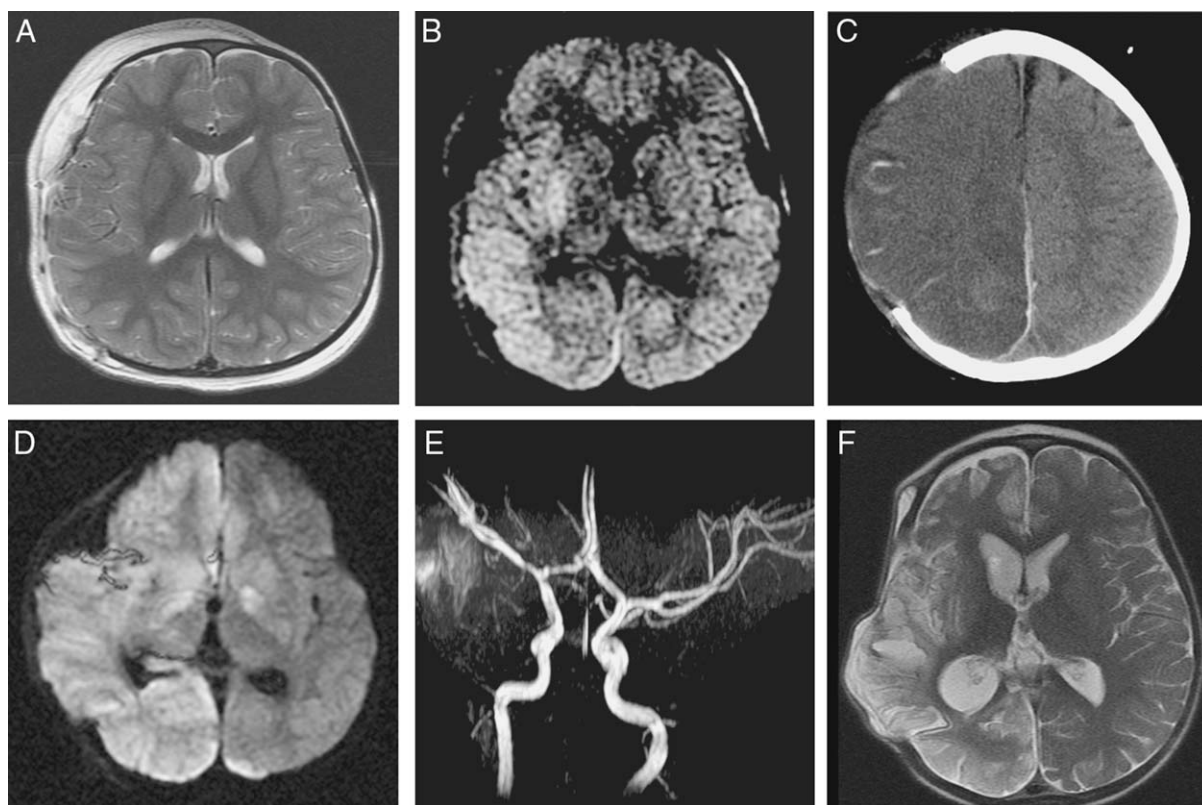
Two-year-old girl with injury, suspicious for inflicted trauma with acute right subdural hematoma. She had a seizure witnessed in an outside emergency department, and was unresponsive with a dilated right pupil on presentation. The clot was evacuated and the brain was noted to be slightly full at surgery, so a hemicraniectomy was performed. Intracranial pressure was measured and easily controlled, and excellent brain perfusion was maintained. The patient was intubated but responsive and was able to follow commands. (A) MRI, T2 sequence, done 1 day after surgery. Note symmetric appearance of brain parenchyma. (B) Diffusion-weighted sequence. Note bright signal in basal ganglia and temporal and occipital cortex. (C) CT scan, postoperative day 3. Note development of hypodensity of entire right hemisphere, with increased swelling. (D) MRI, diffusion sequence, one week postoperatively. Note bright signal in entire hemisphere, as well as contralateral basal ganglia. (E) MR angiogram. All arteries appear patent. (F) MRI, fast spin-echo T2 weighted sequence, 2 months post-injury. Note widespread damage to right hemisphere. The patient has a hemiparesis and hemianopsia.
